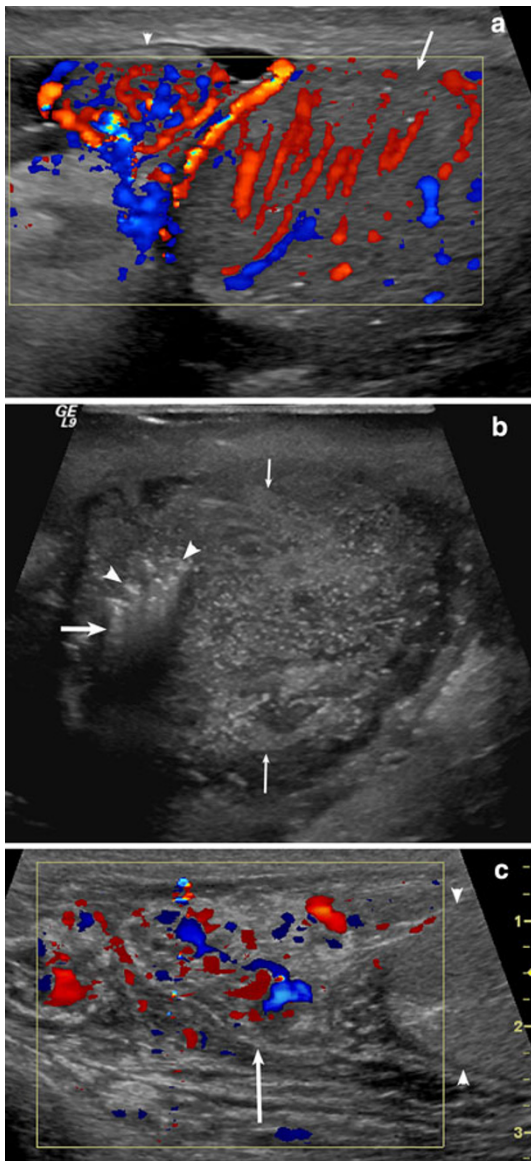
Epididymo-orchitis and complications. a Epididymo-orchitis. Longitudinal color Doppler US in a 31-year-old with acute left scrotal pain and recent diagnosis of *Chlamydia trachomatis*. There is extensive hyperemia of the epididymal head (arrowhead) and testis (arrow) compared to the contralateral side (not shown). The patient's symptoms resolved after treatment with doxycycline. b Scrotal abscess. Transverse US image of the left testis in a 59-year-old paraplegic patient with recurrent epididymo-orchitis and scrotal abscesses. The left testis is nearly replaced by a heterogeneous fluid collection (small arrows). In the medial aspect, there is a cluster of echogenic foci (arrowheads) which result in reverberation artifact/ 'dirty shadowing' (large arrow) due to a gas component. Cultures following surgical drainage grew *Pseudomonas aeruginosa* and *Enterobacter cloacae*. c Vasitis. Longitudinal US image of the left inguinal canal in a 46-year-old with left scrotal and pelvic pain. There is hyperemia of the epididymal head and spermatic cord (arrow) as it traverses the inguinal canal. Note the normal-appearing superior aspect of the testis (arrowheads). d Vasitis. Axial CT image of the pelvis (same patient as in part c) shows an enlarged and inflamed left vas deferens (arrows). The right vas deferens is normal (arrowheads). The patient's symptoms resolved after treatment with Ciprofloxacin
